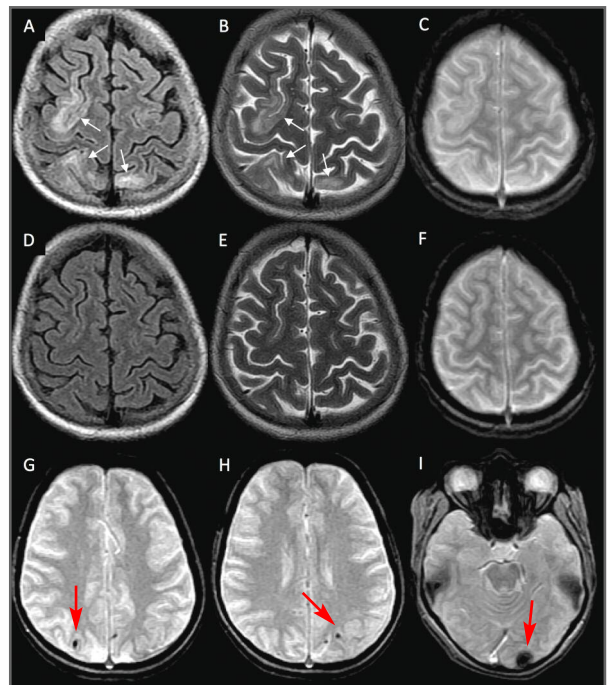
FLAIR and T2-weighted sequences of MRI (Brain) depict hyperintense lesions involving the frontoparietal cortices (A and B, arrows), which show complete resolution at 6 months (D and E). Initial T2* (C) and follow-up (F) sequences of the involved regions did not reveal any hemorrhagic foci. T2* images (G-I) reveal the presence of multiple hemorrhagic foci (blooming) spread across the brain parenchyma
